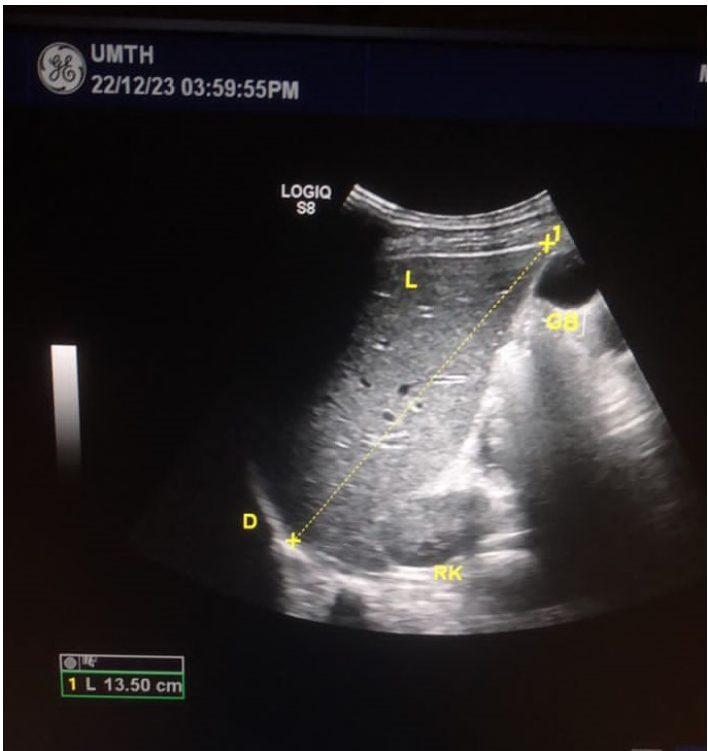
Liver span measurement technique. Longitudinal sonographic image in mid-clavicular line showing measurement from hepatic dome to inferior liver edge during deep inspiration. Keys: L = Liver; RK = Right Kidney; GB = Gall bladder; D = Diaphragm.
